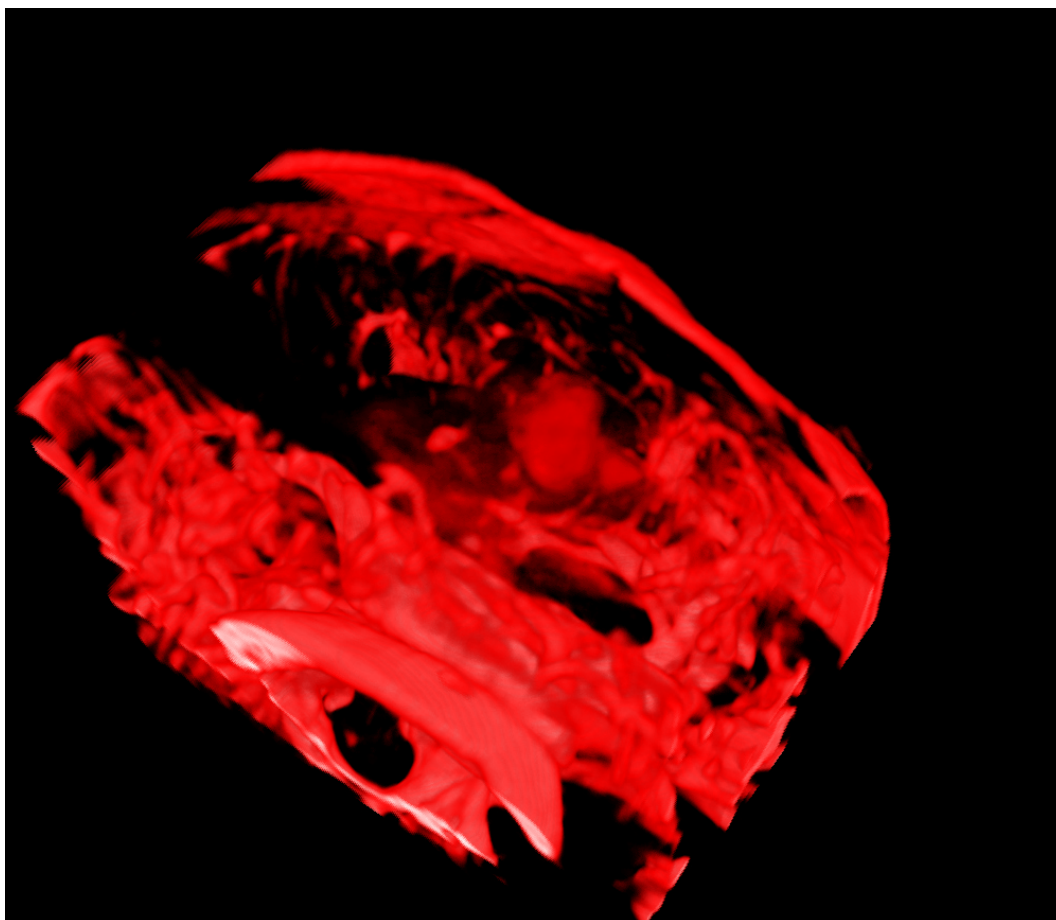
Tumor 1, phase 2. Volume rendering of MRI T2 (*red*) before registration.
